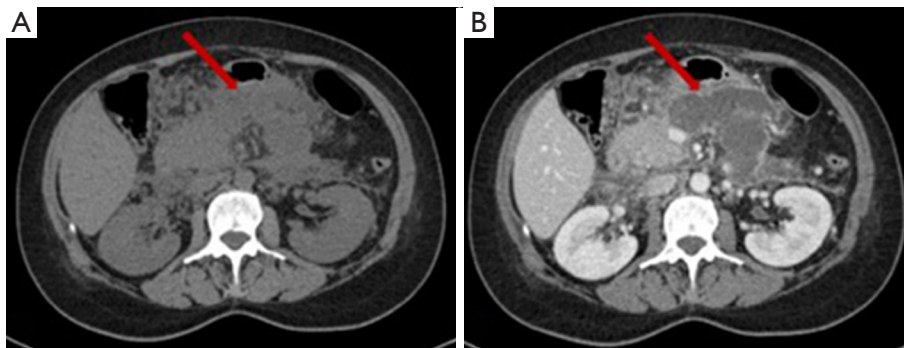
Pseudocyst: red arrows indicate pseudocyst in unenhanced (A) and in enhanced portal phase (B) CT examination. CT, computed tomography.
